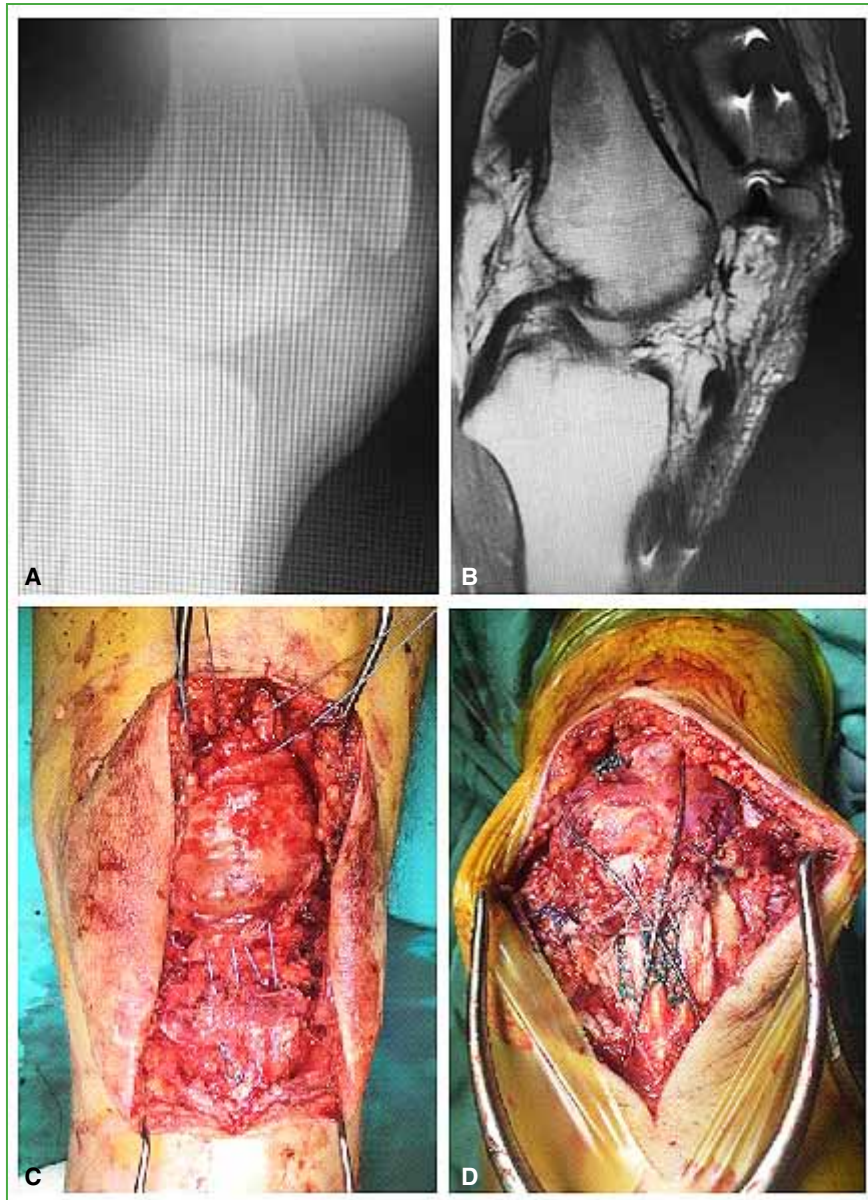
A 43-year-old man with a ruptured patellar tendon, who underwent repair by a transosseous suture in the patella and protection with cerclage. A. Lateral knee radiograph showing superior patellar displacement. B. Knee MRI, sagittal plane. Note the proximal rupture of the patellar tendon. C. Krackow stitches on the tendon and passage of the suture through bone tunnels. D. Final assembly with the protective figure-of-eight cerclage wire.
